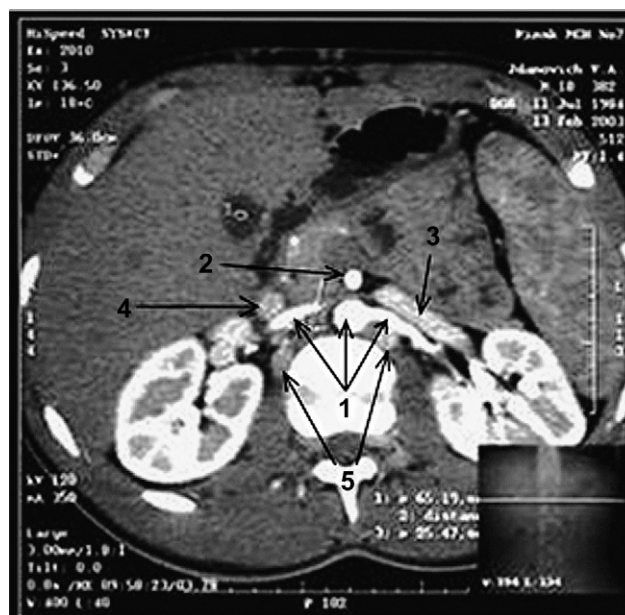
Spiral CT (transverse section at the L<sub>2</sub> level). 1 – aorta and renal arteries, 2 – superior mesenteric artery, 3 – left renal vein, 4 – stria corresponding to IVC, 5 – ascending lumbar veins.
